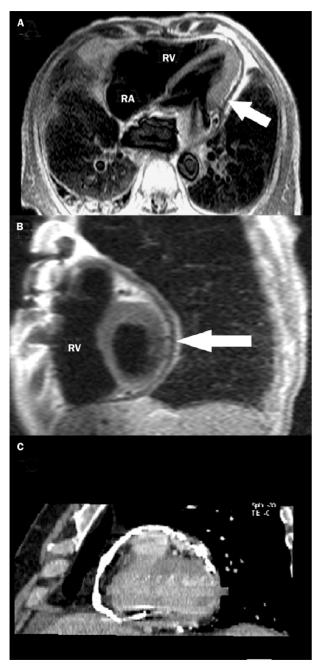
MRI and CT images showing features of constrictive pericarditis
